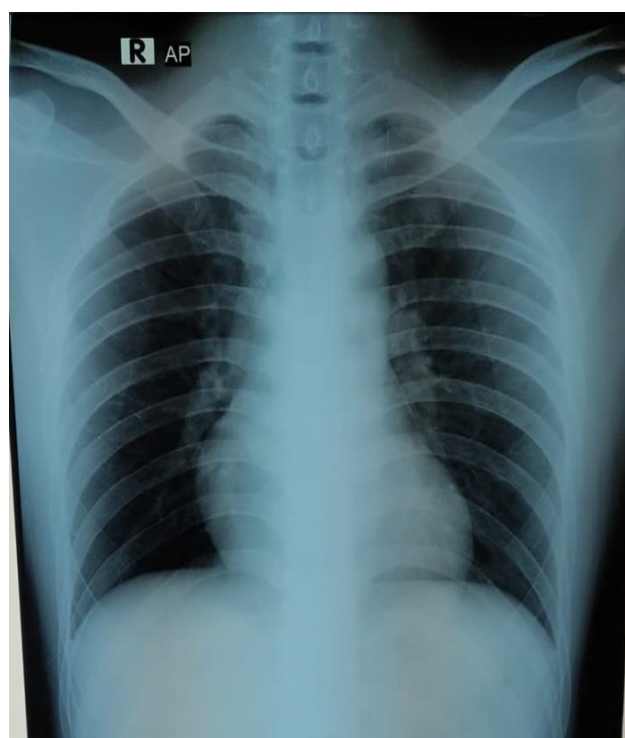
Thoracic antero-posterior (AP) X-ray imaging showed within normal limit
